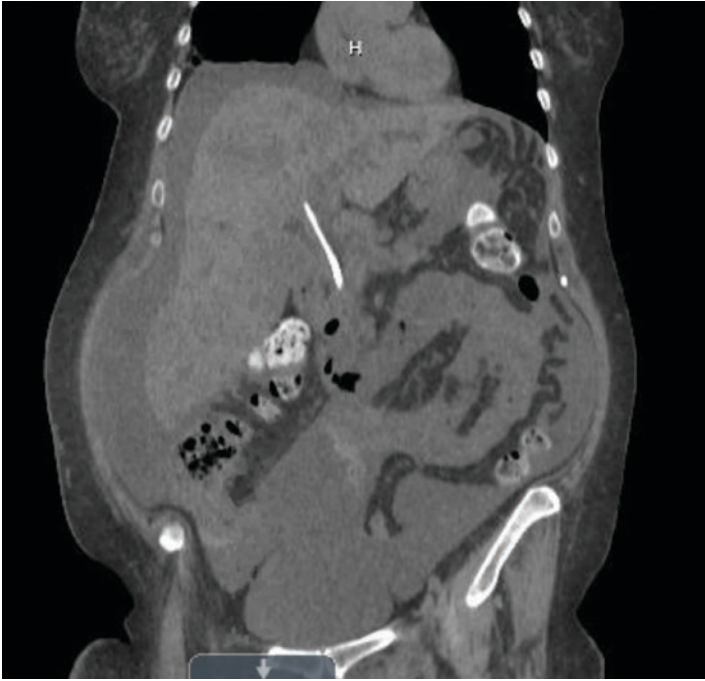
CT abdomen with previously placed plastic biliary stent and intrahepatic biliary dilation from metastatic colon cancer. (Courtesy of Ryan Law, DO, University of Michigan)
